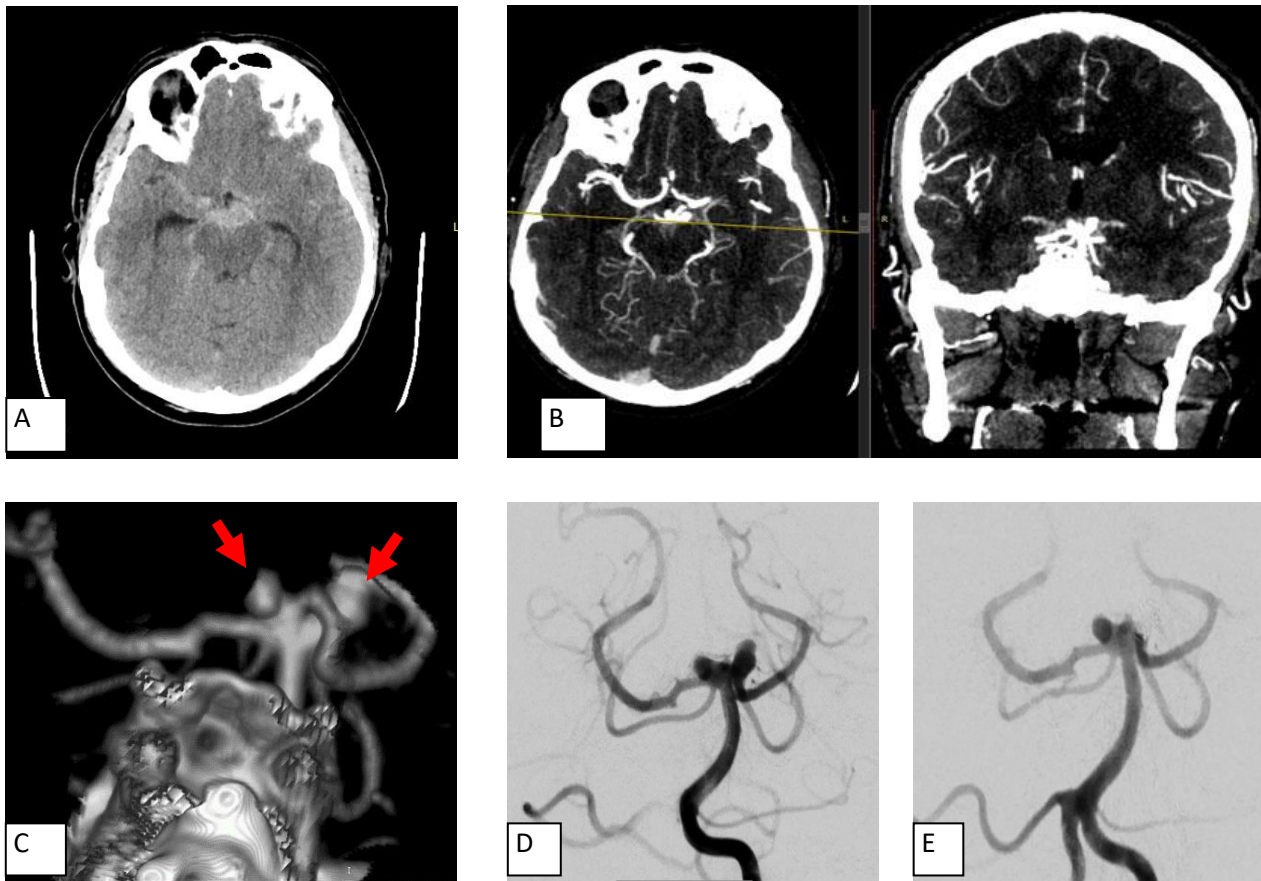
A - First head CT examination at the local hospital showing a SAH; B - brain CT angiography revealing a double basilar tip aneurysm; C - CTA 3D reconstruction; D - DSA in working projection; E - DSA control after basilar artery-superior cerebellar artery junction aneurysm coil occlusion.
